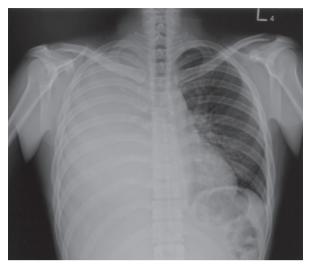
Chest X-ray showing total opacification in the right-side lung field and a massive amount of right-side pleural effusion.
